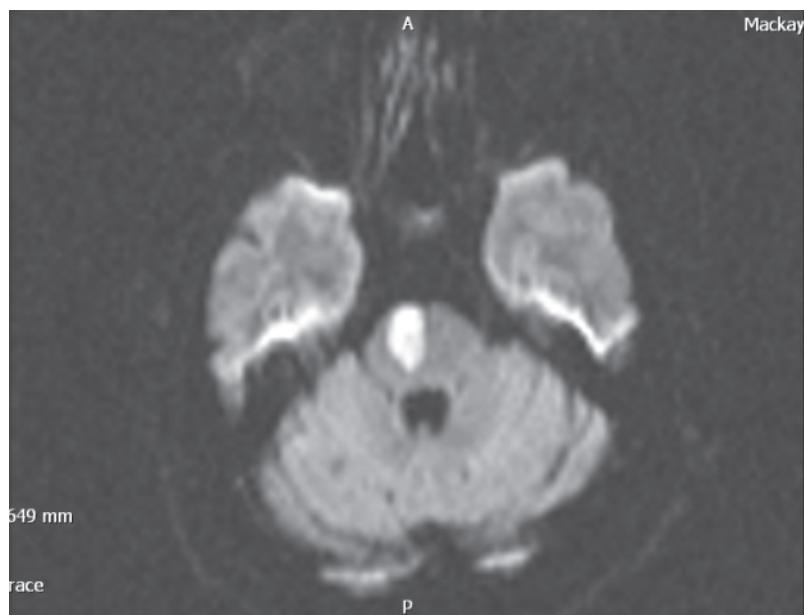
Brain MRI (DWI) revealed a right ventral pontine infarct.
